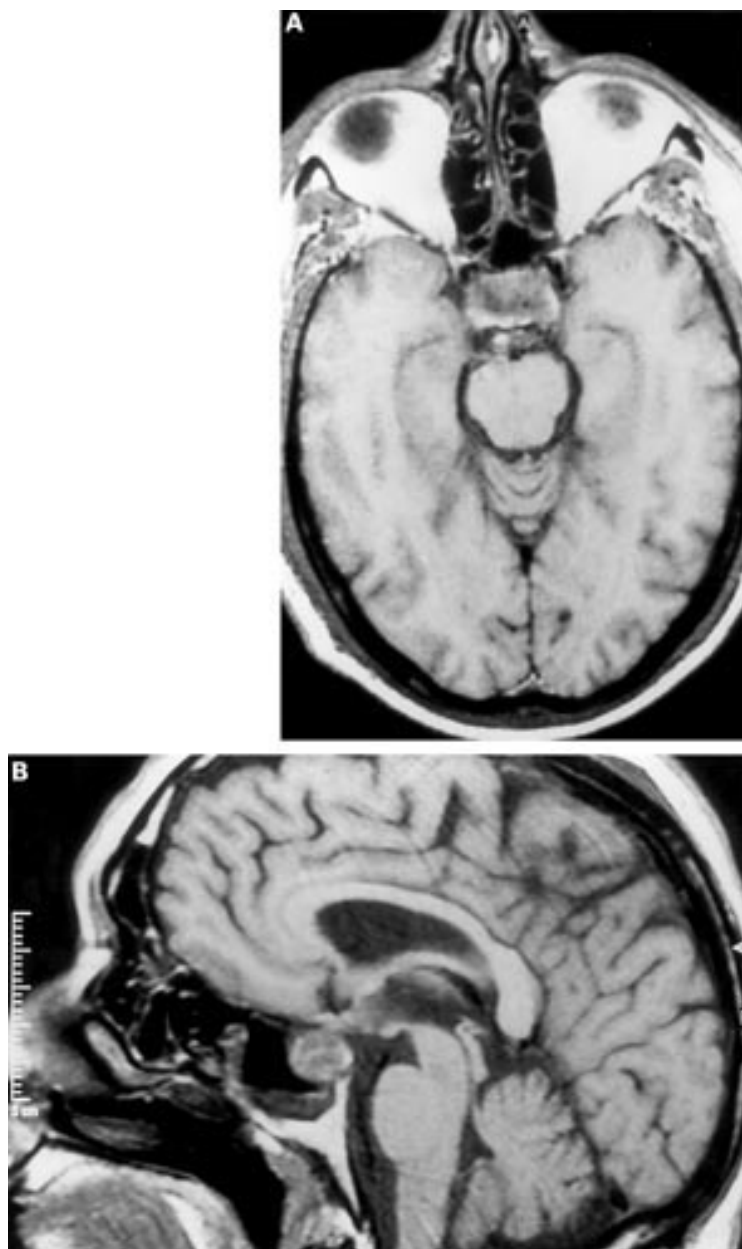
Acute pituitary apoplexy in a 68 year old man who developed acute headache and bilateral complete third nerve palsies 48 hours after coronary artery bypass surgery. His level of consciousness was normal and the remainder of his neurological examination was unremarkable. The initial investigation specifically looked for a haemorrhagic or ischaemic cerebrovascular accident at the level of the midbrain, and the diagnosis of pituitary apoplexy was delayed by 24 hours. The patient underwent transphenoidal decompression 48 hours later (after his cardiac condition was stabilised) and he completely recovered. (A) Axial T1 weighted MRI of the brain showing a normal brain stem and an enlarged pituitary gland which is heterogeneous, consistent with an infarction of the pituitary gland with a mild haemorrhagic component. (B) Sagittal T1 weighted MRI of the brain demonstrating the enlarged pituitary gland.
